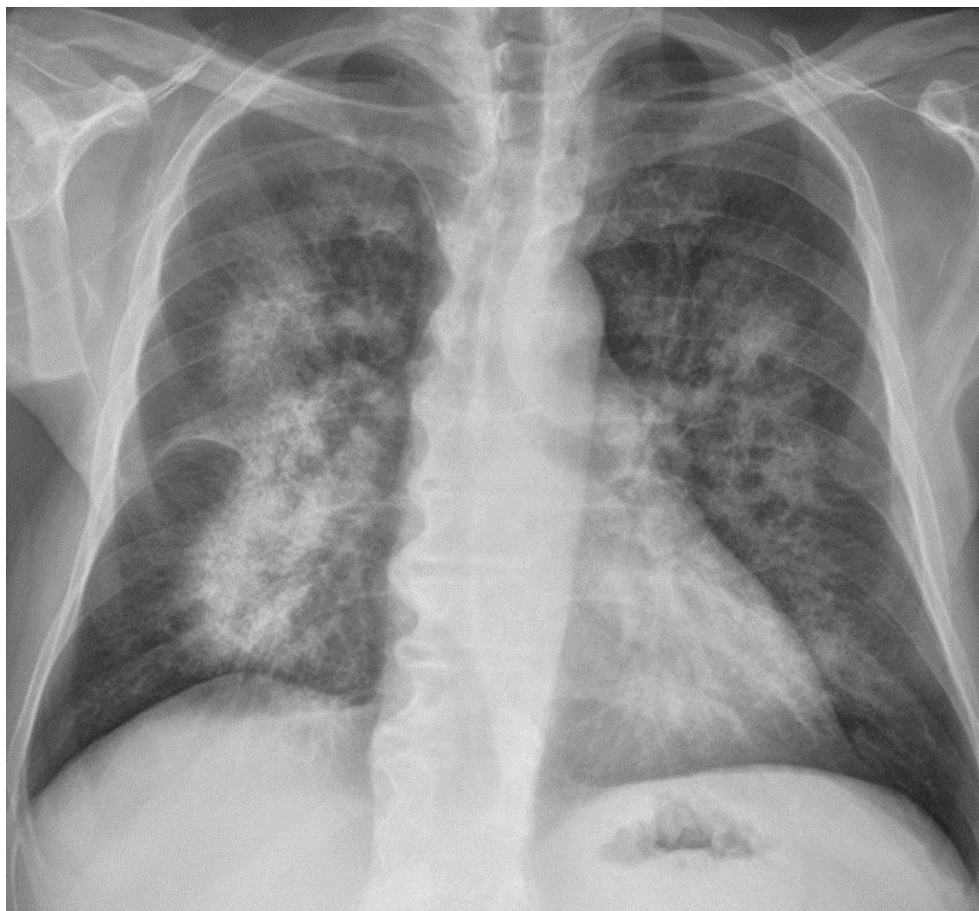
Repeat chest radiograph 4 months after the initial chest radiograph.
